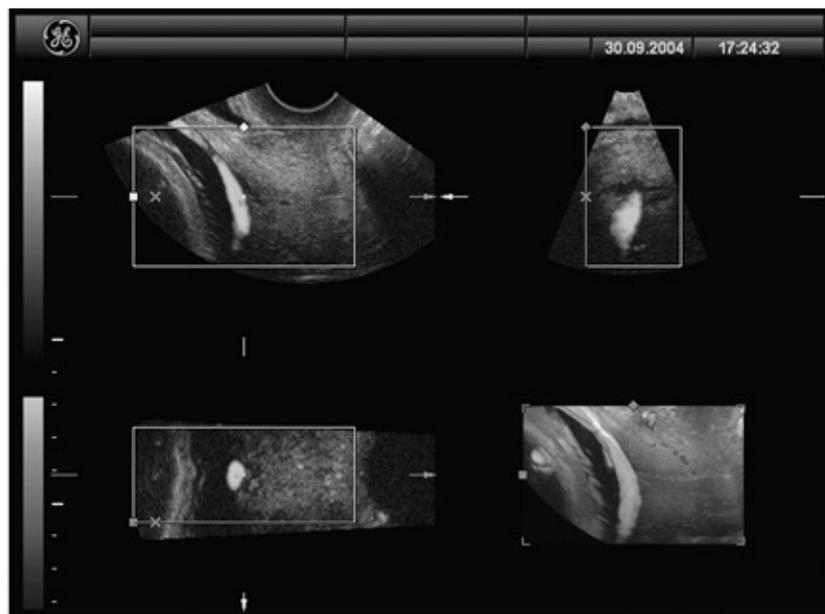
Multiplanar transvaginal 3D sonogram of the vasa previa at 34 weeks gestation. A: Sagittal view showing a vessel running in a sagittal direction over the internal os. The *arrow* points to the internal os. B: Coronal view showing a cross section of the vessel just behind the internal os. The *arrow* points to the internal os. C: Transverse view with the reference dot at the internal os showing the vessel crossing the cervix just at the level of the internal os, to which the *arrows* point. D: Three-dimensional reconstruction of the vasa previa. (From Canterino JC, Mondestin-Sorrentino M, Muench MV, et al. Vasa previa. *J Ultrasound Med* 2005; 24:721-724, with permission.)
